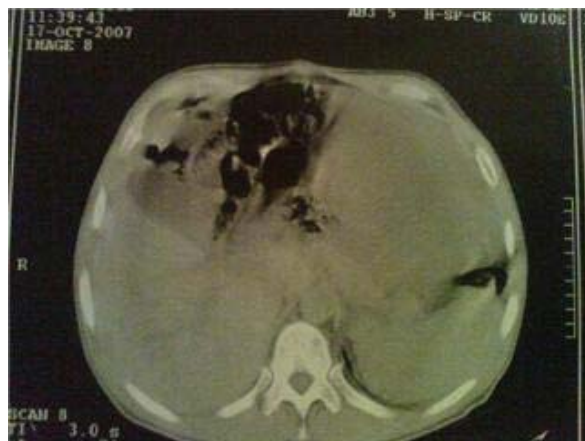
CT scan of abdomen: heterogeneous mass 285x207 mm.
